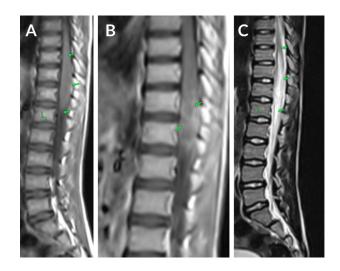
T1W (A), T1W postcontrast (B), and T2W (C) sagittal thoracolumbosacral MRI images show a long-segment spinal cord expansion from T10 to T12, appearing hypointense on T1W, hyperintense on T2W, and showing heterogeneous enhancement on T1W postcontrast.
